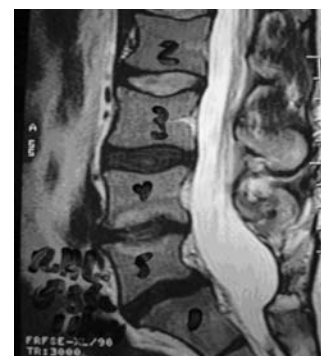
Nuclear magnetic resonance image, at sagittal plane, showing discopathies at L3-L4, L4-L5 e L5-S1 levels (black discs).
